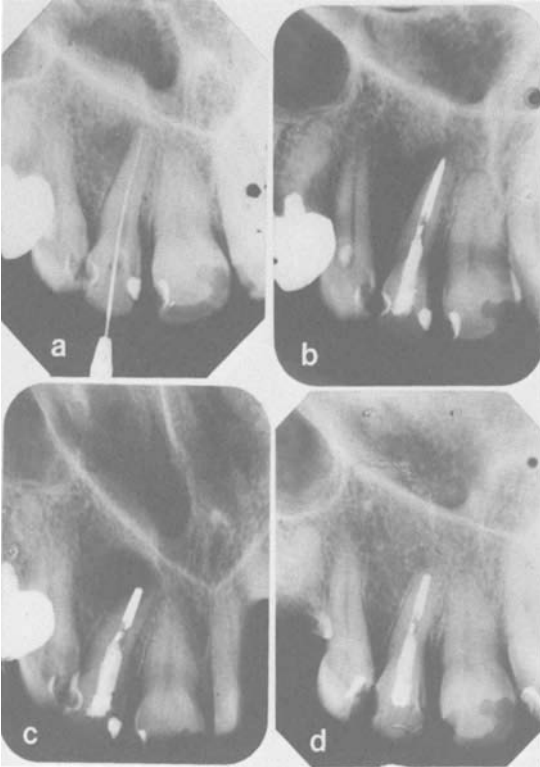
Treatment of 2 | periapical lesion by apicectomy after apical filling with amalgam. (a) Before treatment. (b) Immediately after root filling. (c) Immediately after apicectomy. (d) Six months post-operative. (e) Twelve months post-operative. (f) Two years post-operative.
